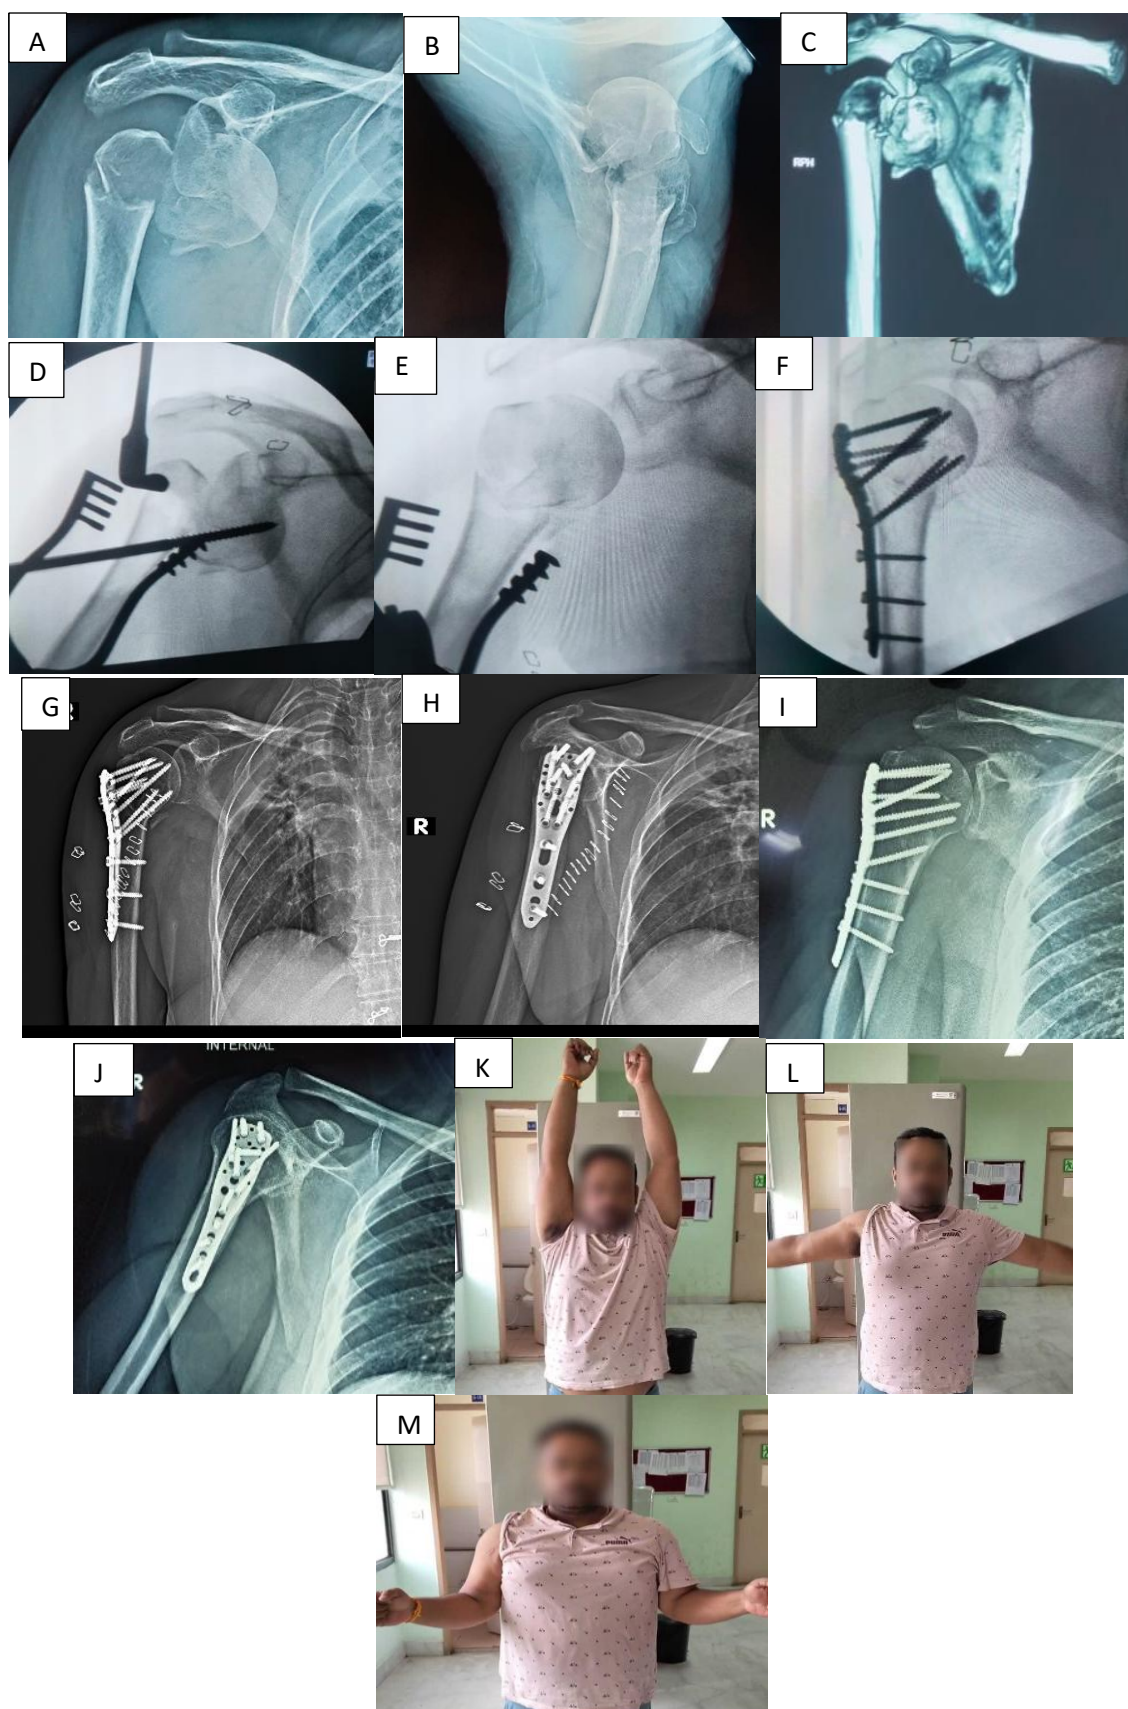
(A-C) 35 year old male patient-pre op X-ray and CT showing proximal humerus fracture dislocation (Neer's 3 part); (D-F) Intra op C-arm images showing retrieving the humerus head with Steinman and fixed with philos plate; (G-H) Post op X-ray; (I-J) X-ray at the end of 1 year showing good bony union; (K-N) Patient showing good range of motion at the end of 1 year with CMS score of 78.
